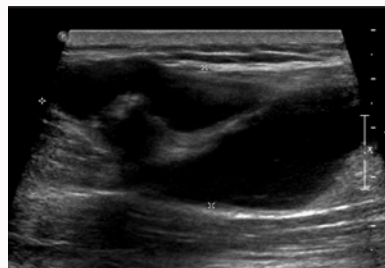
Ultrasound imaging (sagittal view), demonstrates large, hypoechoic, loculated mass.
